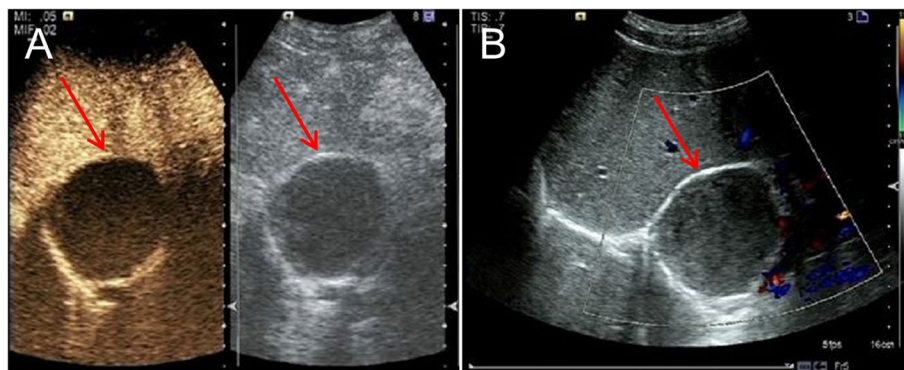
Imaging findings. A-B Ultrasound contrast examination showed a cystic mass in the anterior right lateral aspect of the right atrium, with no significant enhancement and clear boundaries (red arrow)
